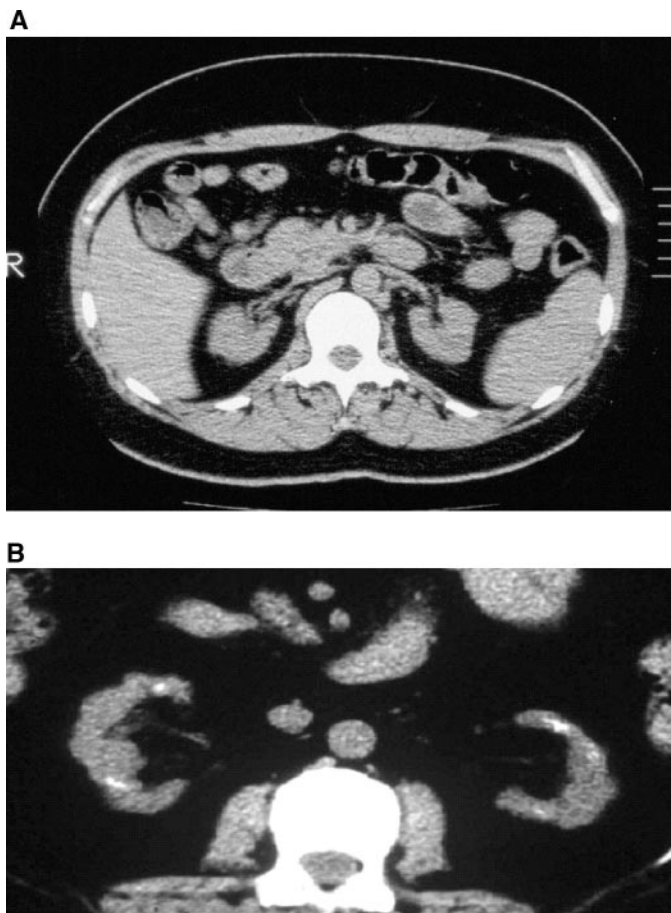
(A) Typical computerized tomography (CT) appearance of a patient without small indented calcified kidneys (SICK) and with ESRD; this pattern was seen in 65% of patients. Note that both kidneys are small and show no parenchymal scars or calcifications. (B) CT findings of a patient with grade 3 SICK. Both kidneys are small and demonstrate bilateral parenchymal scars and coarse papillary calcifications.
